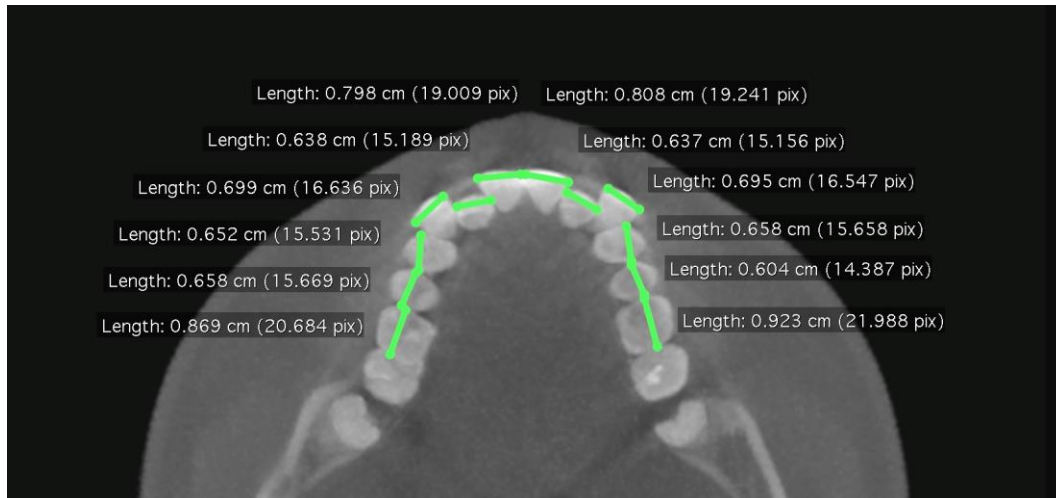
CBCT measurements on Osirix to determine the sum of tooth widths.
